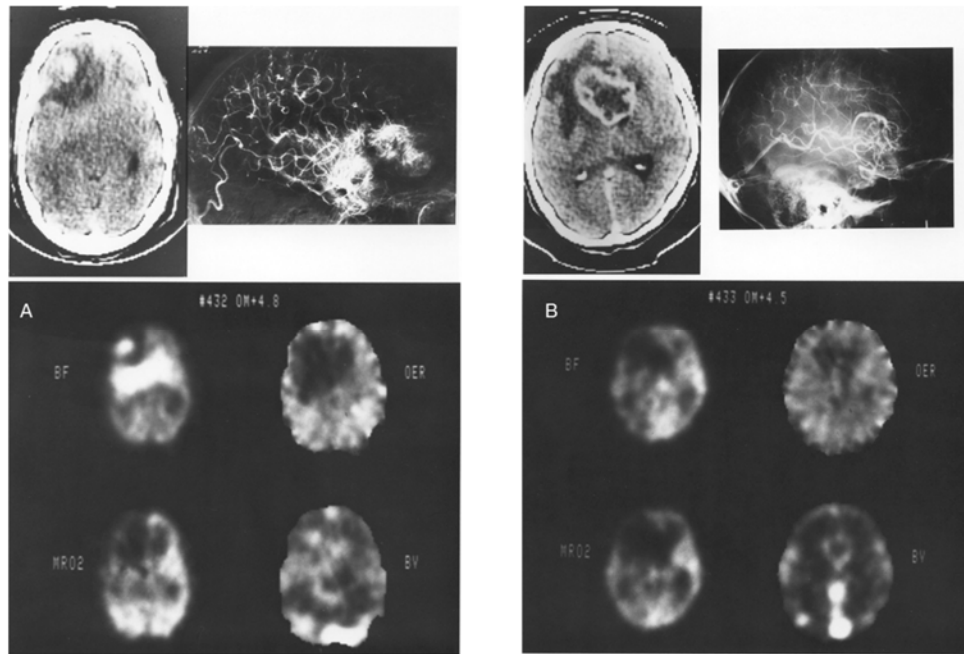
Parametric cerebral blood flow (BF), oxygen extraction fraction (OER), oxygen metabolism (MRO2) and blood volume (BV) images of (A) an astrocytoma, Kernohan grade IV, and (B) a glioblastoma multiforme, Kernohan grade IV. CT images and angiograms are shown above these parametric images. BV in both tumours is increased, which corresponds with the pattern seen in the angiograms. BF, however, is very different between the two tumours. Despite this difference in perfusion, oxygen extraction is reduced in both tumours as compared with normal cerebral tissue.
